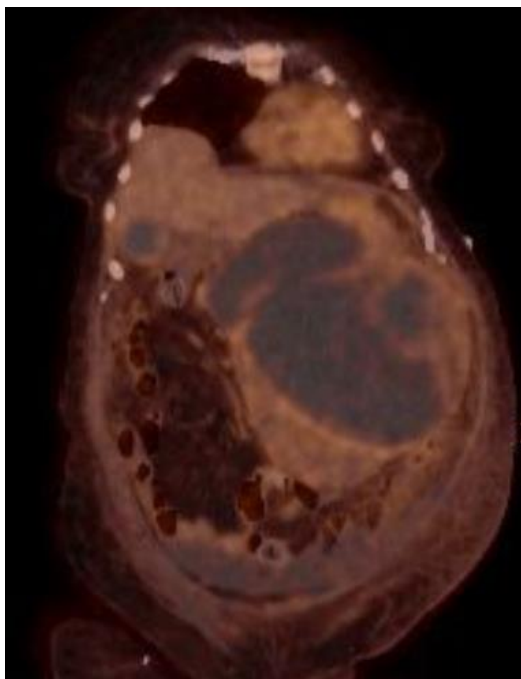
PET CT reveals a giant mass occupied a majority of the abdominal cavity
